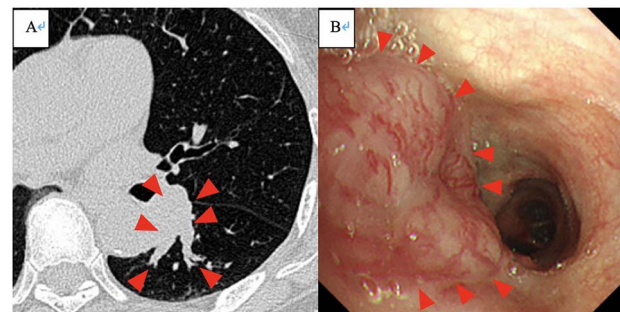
(A) Chest computed tomography scan showing mucoid impaction-like finding in the left lower lobe (red arrowheads). (B) Bronchoscopy revealing the total occlusion of the apical bronchus of left lower lung by the mass with angiogenesis (red arrowheads).
